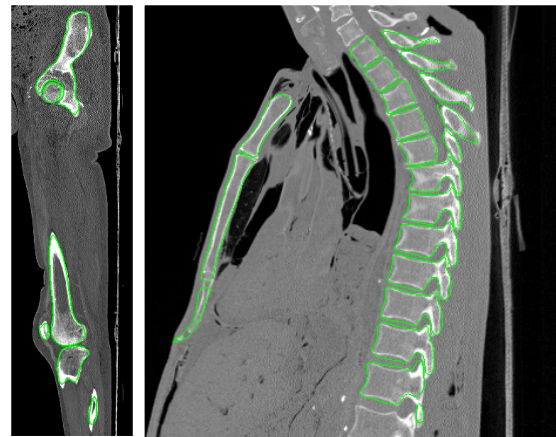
The green registered surface projected on a slice of the target PMHS CT-scan. Left: pelvis, lower limb. Right: sternum, thoracic vertebrae. Accuracy of registration: a Dice coefficient of 0.91 for a femur.
